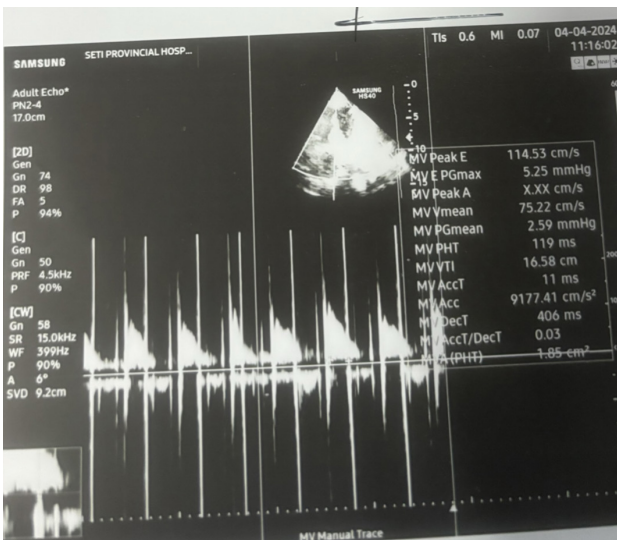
Echocardiography showed high peak and mean MV gradients (17 and 6 mm Hg, respectively) on the first day of admission (C) and reduced peak and mean MV gradients (5 and 2 mm Hg, respectively) on the 3rd day of admission (D).
